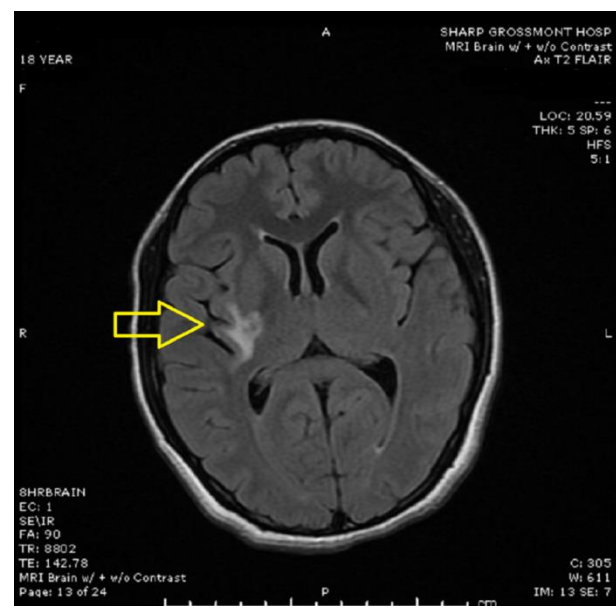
Magnetic resonance imaging (MRI) of the brain with contrast showing a lobulated lesion measuring approximately 1.6 cm in maximal dimension (yellow arrow) centered in the inferior right basal ganglia and with peripheral enhancement
